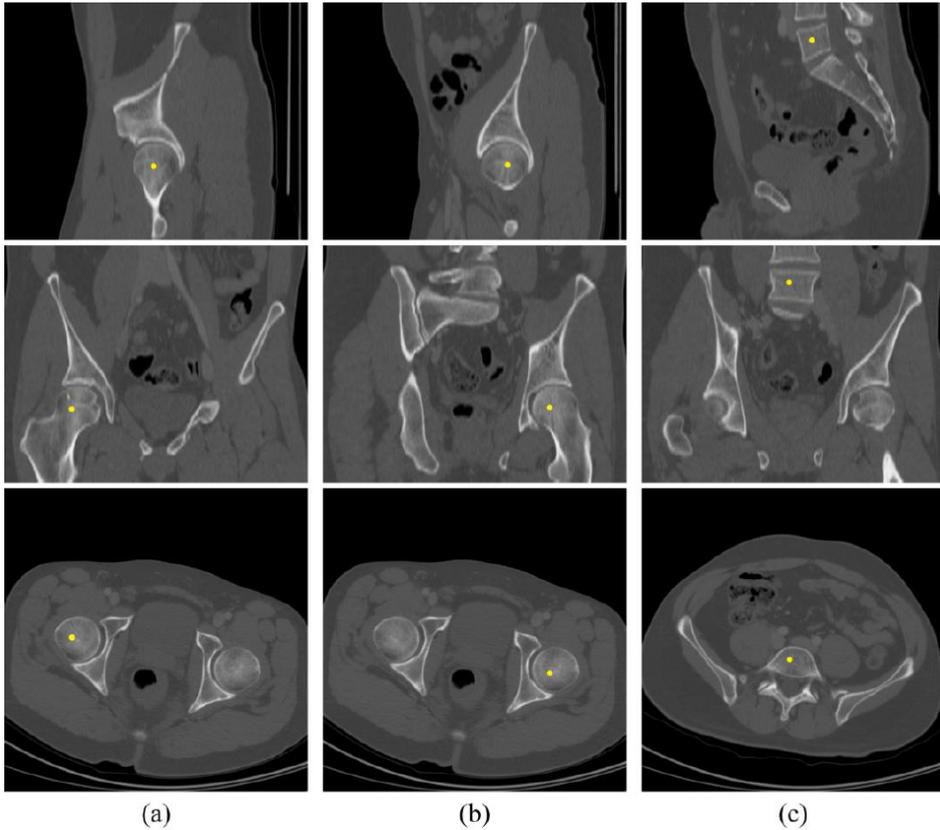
The manually defined approximate centers of (a) the left femoral head, (b) the right femoral head and (c) the L5 vertebral body, which served to initialize the computerized method for the determination of ischio-iliac angle, shown in corresponding sagittal (*top*), coronal (*middle*) and axial (*bottom*) CT cross-sections of a selected subject.
